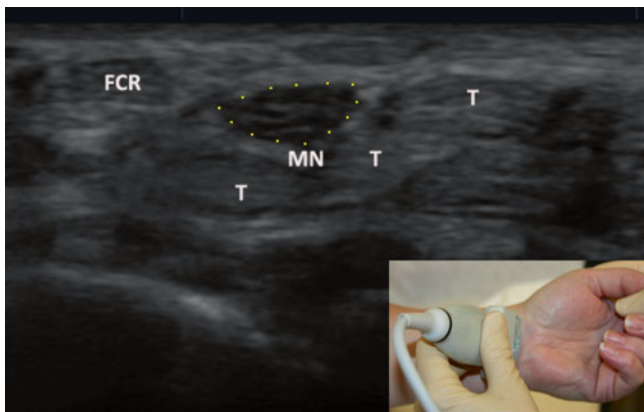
Ultrasound image of the wrist at the carpal tunnel. *T* tendon, *FCR* flexor carpi radialis, *MN* median nerve (Image courtesy of Virtaj Singh, MD)
